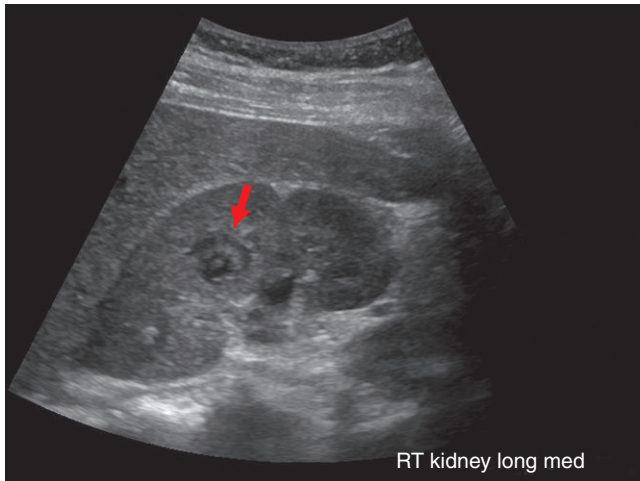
Longitudinal ultrasound in another patient demonstrating hypoechoic region noted within the right kidney corresponding to a small renal abscess (arrow).
